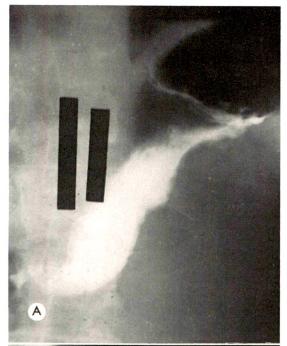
Carcinoma of the head with extension to body and tail. (A and B) Posteroanterior and left lateral upright roentgenograms. Note characteristic location and type of indentation due to the tail. It is just below the fundus on the lesser curvature, and indents the posterior wall at the same level. (C) Note bulbar defect with ulceration, postbulbar narrowing with distal distention with ledge formation due to the mass, partial obstruction at 3rd portion of the duodenum with irregularity of mucosa with erosions at the 3rd portion of the duodenum. (D) Right lateral recumbent roentgenogram. The enlargement of the retrogastric space is debatable due to the wrap-around effect. Fortuitously, the mass indents the gas filled colon. The descending duodenum is displaced anteriorly, especially inferiorly. The superior portion of the descending duodenum presents a widening and separation of the folds with picket fence formation.
